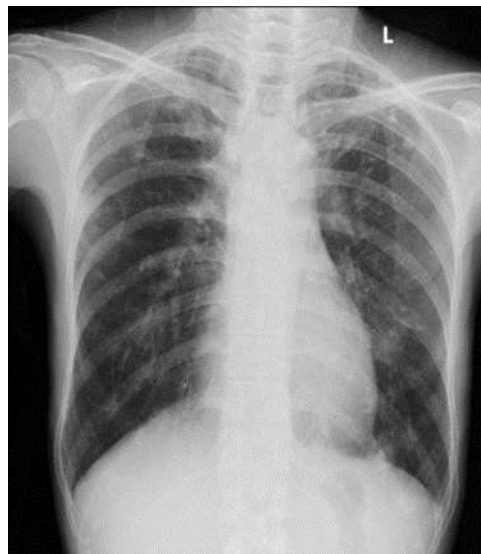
Results of thoracic X-ray examination.
